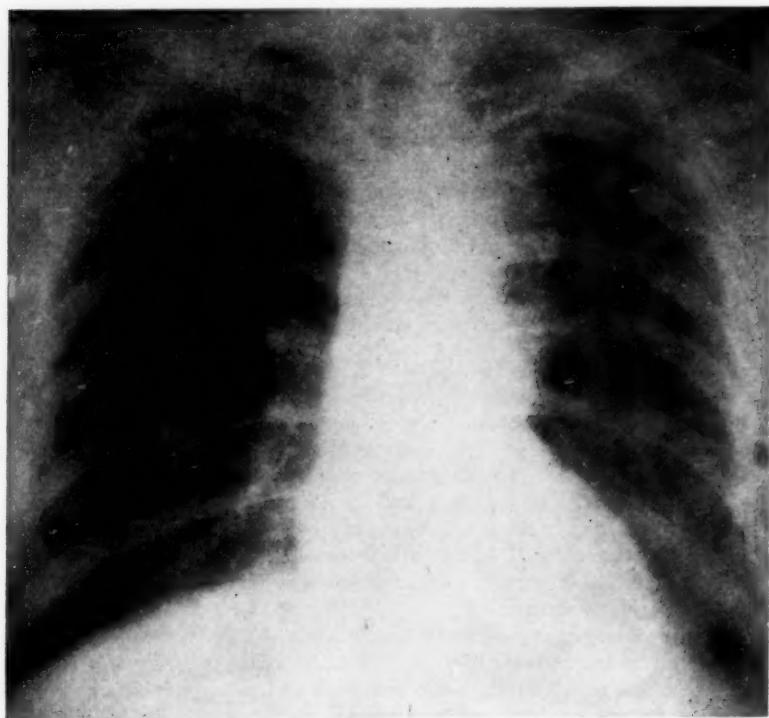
Roentgenogram of 4-13-31, showing the shadow adjoining the left upper mediastinum. (Details in the text.)
